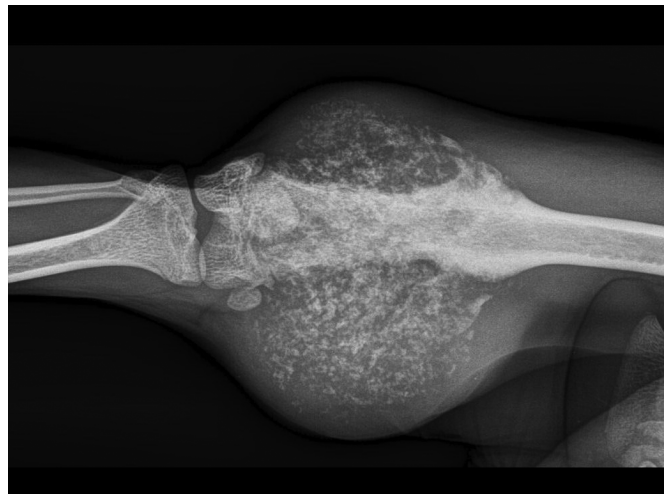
Radiography of the femoral mass revealed a large mass with moderate radiopacity and multifocal floccular mineralization. The underlying bone is characterized by diffuse cortical lysis, patchy remodeling processes involving the medullary cavity, and cortical thickening at the proximal margin of the lesion. There is obvious soft tissue extension.
